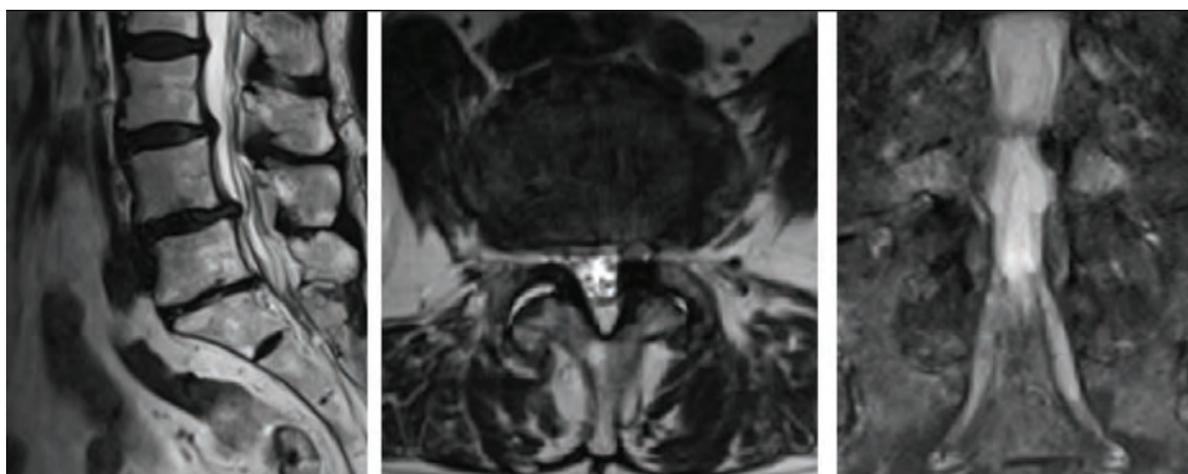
MRI of the lumbar spine showing L4-L5 degenerative spondylolisthesis and foraminal narrowing.
